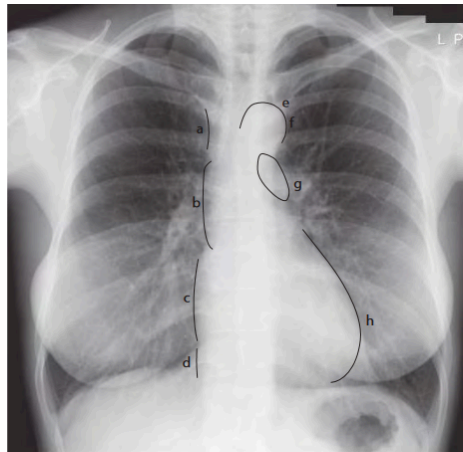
PA chest radiograph (a), Superior vena cava. (b), Ascending thoracic aorta. c, Right atrium. d, Inferior vena cava. e, Left subclavian vein. f, Aortic knuckle. g, Main pulmonary artery. h, Left ventricle
